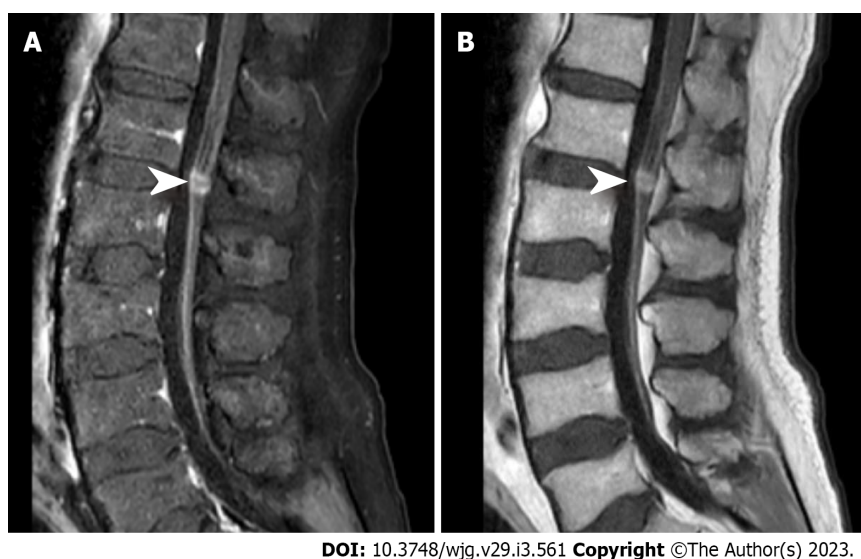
Magnetic resonance imaging showed local abnormally enhanced nodules (white arrow) at the L1/L2 level in the cauda equina. A: T1 phase; B: T2 phase.
